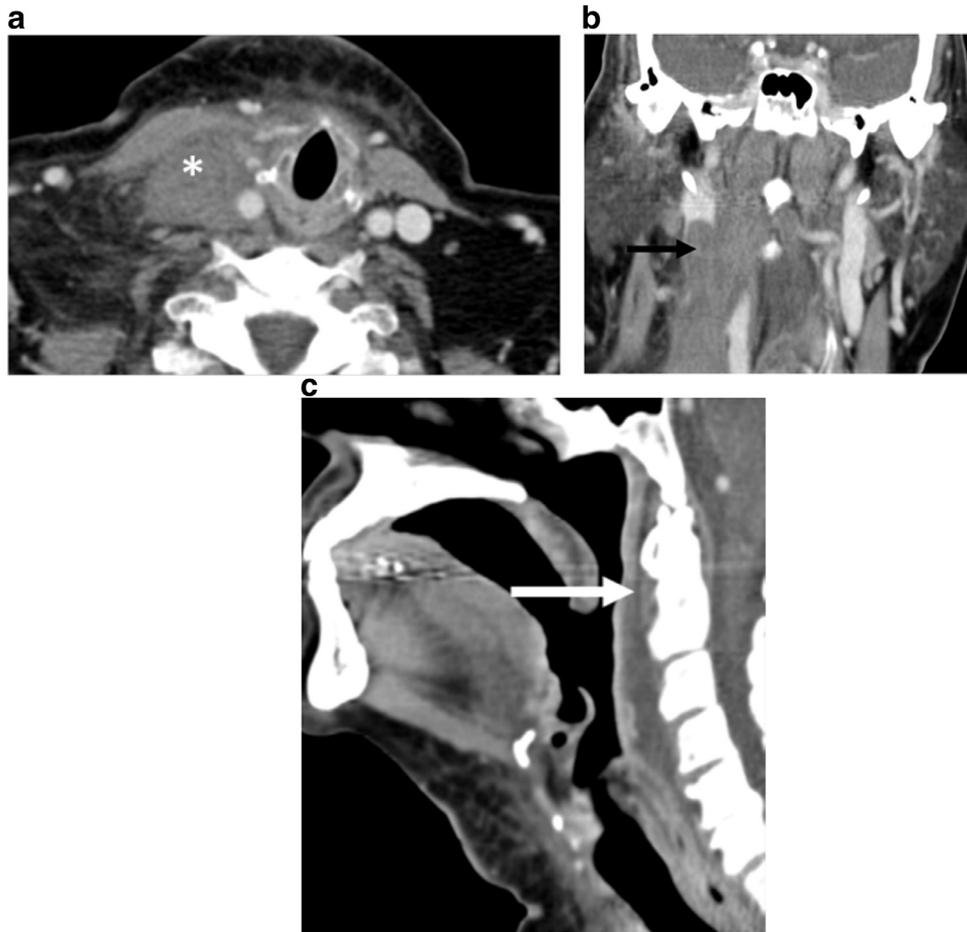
Lemierre's syndrome. Seventy-two-year-old male presented with neck swelling and difficulty breathing with physical exam consistent with pharyngitis. CT neck revealed fat stranding of the right parapharyngeal space (*) with thrombosis of the right internal jugular vein consistent (black arrow). There is trace retropharyngeal fluid (white arrow).
